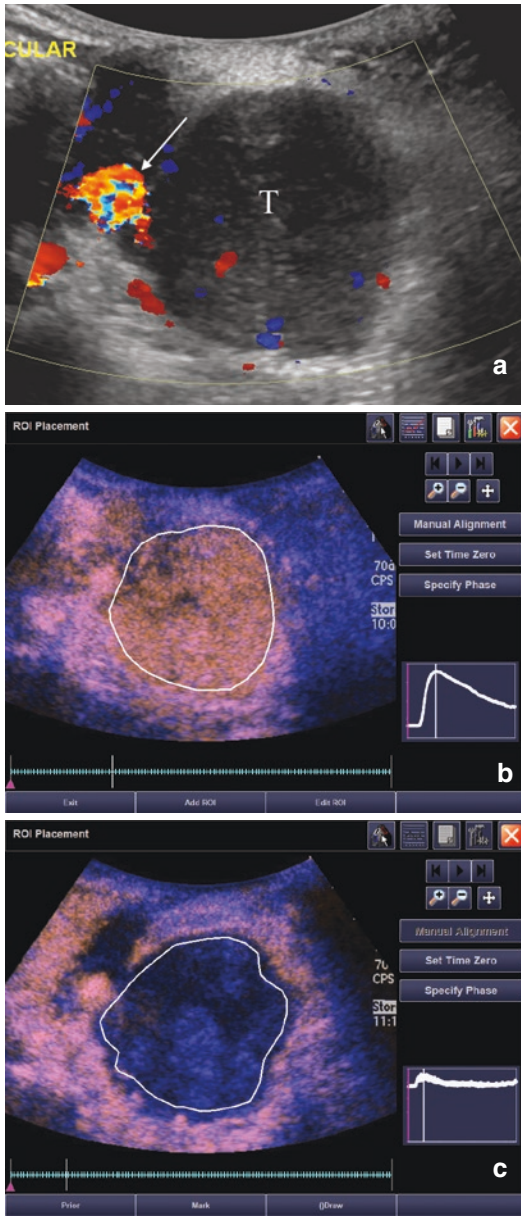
A 15-year-old girl with recurrent synovial sarcoma. (a) Transverse color Doppler grayscale sonogram of the largest transverse area of a left supraclavicular tumor (T). Common carotid artery (arrow) was used as a landmark to insure similar transducer placement on follow-up studies. (b) Baseline CEUS with region of interest (ROI, solid line) drawn just inside tumor margins. Vertical line in the inset time-intensity curve indicates that this image was obtained at peak enhancement (PE) of 28.9 dB. (c) Day 7 after initiation of therapy, image obtained at PE of 2.0 dB giving a 93% reduction compared to baseline. This subject’s time to progression was 242 days after initiation of therapy (reprinted with permission from reference [67])
